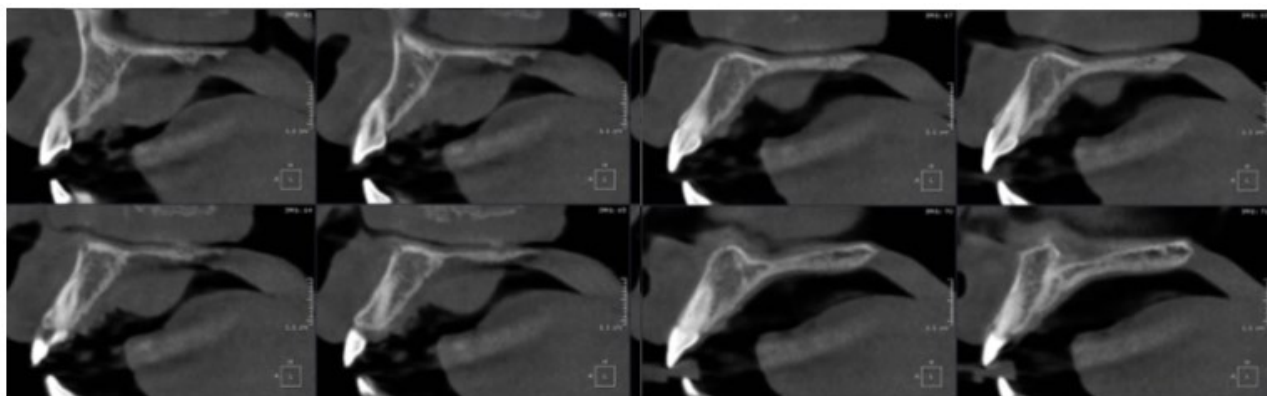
CBCT sagittal slicing of the lesion, it appears that the appearance of the lesion and the border of the lesion are in the posterior line with the surface area of the palate, so that it can be ascertained that the lesion has not extended to the outer areas of the palate¹³
